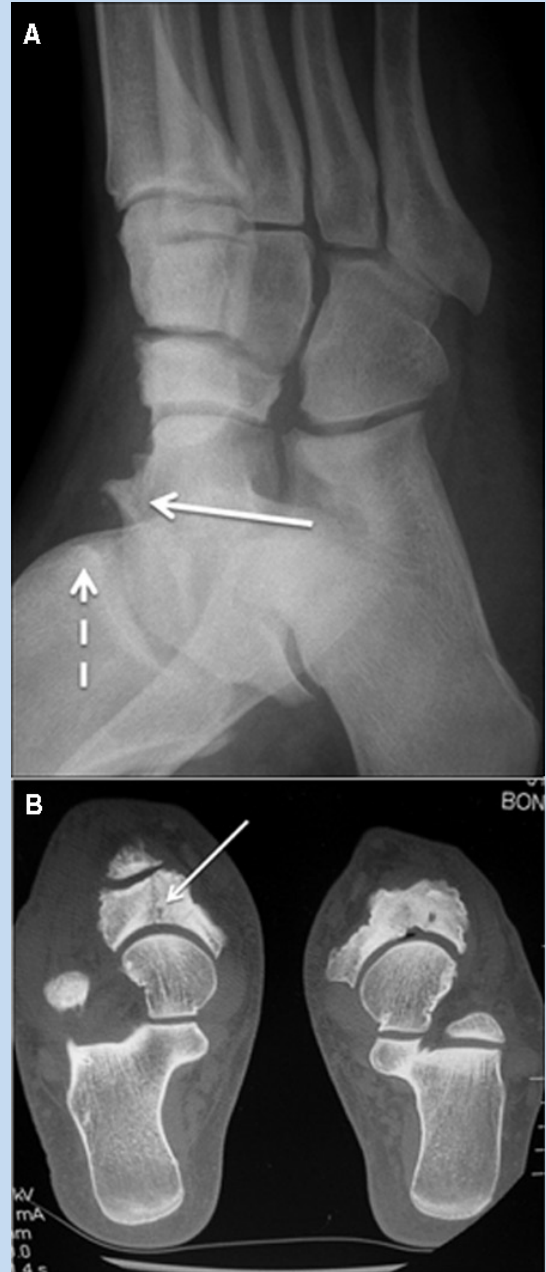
A, a football lineman with a stress fracture of the tarsal navicular and medial impingement symptoms at the ankle—talar spur (solid arrow) and tibial spur (broken arrow); B, axial computed tomography scan of a stress fracture of the right tarsal navicular (solid arrow). The left talonavicular joint has degenerative changes.
